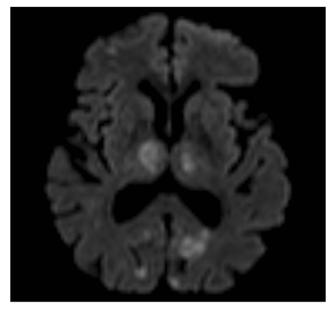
Diffusion weighed imaging (DWI) brain magnetic resonance imaging showing multiple ischemic lesions involving both thalamus and occipital lobes
